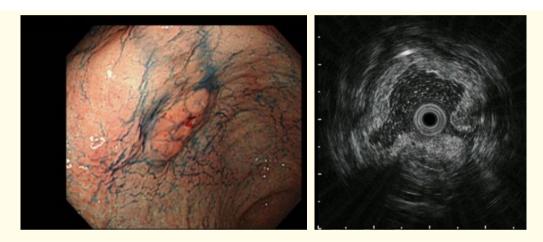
(a) Esophagogastroduodenoscopy reveals a slightly elevated lesion on the anterior wall of the antrum. (b) Endoscopic ultrasonography shows the tumor limited to the mucosa and not surrounded by enlarged lymph nodes.
